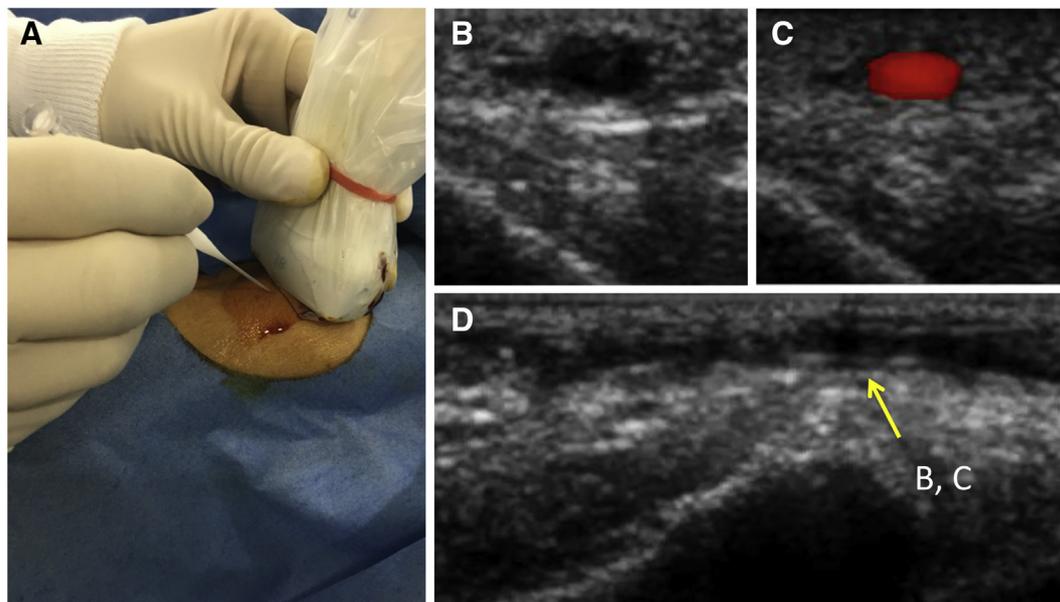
Real-time ultrasound-guided transradial catheterization technique. A. Image shows an ultrasound probe positioned over the radial artery with the needle inserted and advanced toward the radial artery under real-time ultrasound guidance. B. Image shows the radial artery in a short axis view. C. A color Doppler image can be observed. D. Image shows a longitudinal view of the radial artery.
